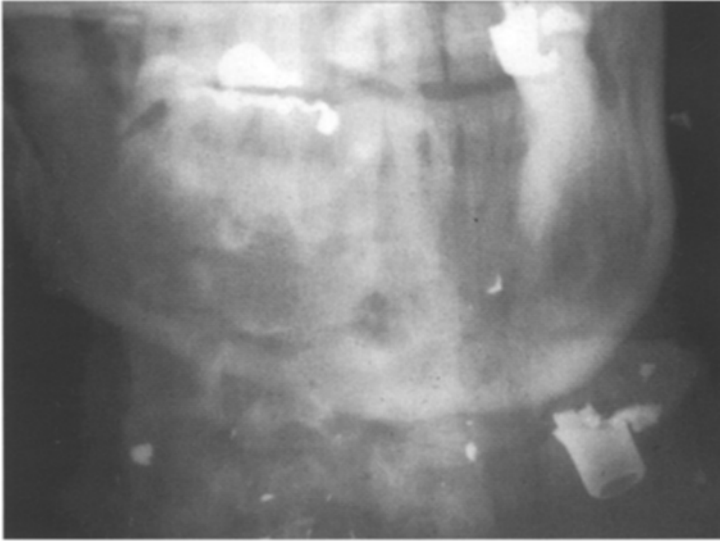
Fragmented bullet within the head and neck areas of a gunshot wound victim. The attending physician at the hospital was puzzled by the presence of one entrance and one exit wound while the projectile appeared retained on radiographic examination, which during autopsy was discovered to be a metallic dental jacket on the second left maxillary molar.
